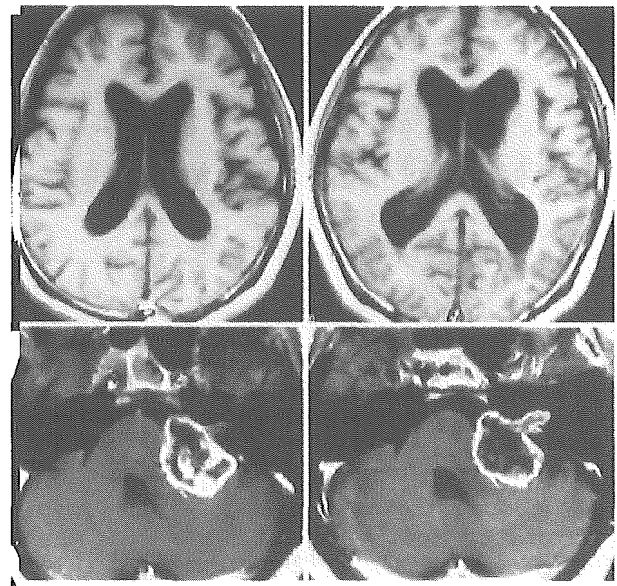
Magnetic resonance images. Upper and Lower Left: At the time of the radiotherapy, this 54-year-old man has a large VS and asymptomatic enlarged ventricles. Upper and Lower Right: Symptoms such as mental deterioration and gait disturbance have become apparent 6 months after radiotherapy, but the VS is stable in size and its central necrosis is evident.
